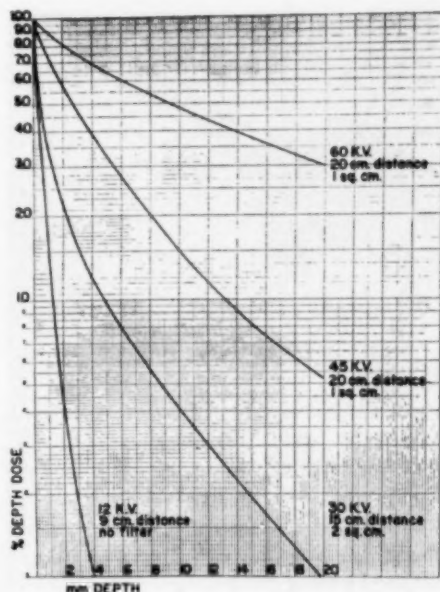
(Hague). X-ray depth dose curves.
